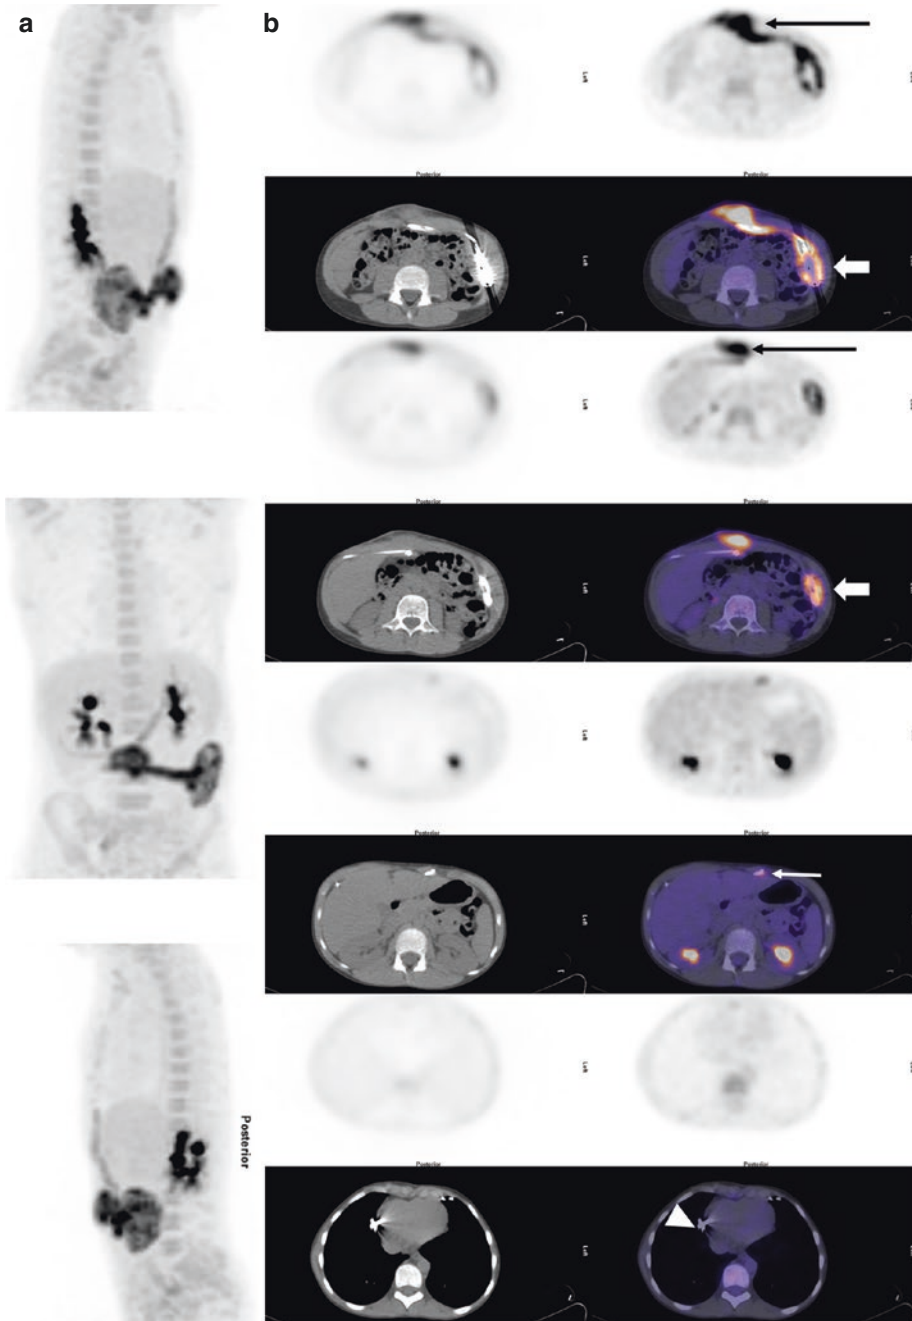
^{18}F -FDG PET/CT of a 9-year-old patient hospitalized for low-grade fever and induration in the epigastric region. The patient had multiple cardiac surgeries for congenital heart disease (double outlet right ventricle) including an epicardial dual chamber pacemaker implantation with implantable pulse generator in the left upper abdominal quadrant for third-degree atrioventricular block. After an inconclusive ultrasound of the latter region, ^{18}F -FDG PET/CT was performed: Maximum Intensity Projections (a) and selected axial images (b).
